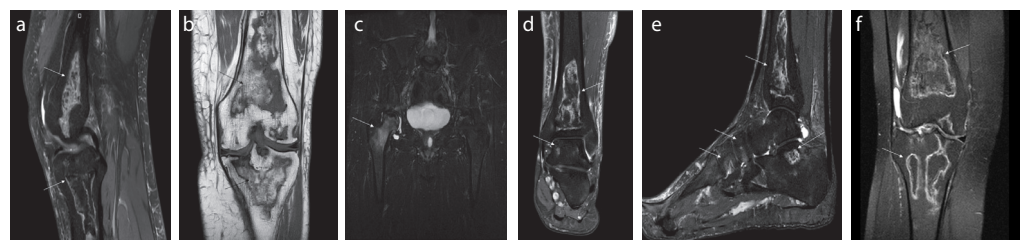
a-f. Multiple osteonecrotic areas (arrows) suggested by nuclear magnetic resonance imaging: Longitudinal short-T1 inversion recovery (STIR) (a) and coronal T1-weighted magnetic resonance image showing proximal tibia and distal femur section (b); coronal STIR magnetic resonance image showing proximal femur section (c); coronal STIR magnetic resonance image showing distal tibia and talus section (d); longitudinal STIR magnetic resonance image showing distal tibia, calcaneus, and first cuneiform bone section (e); and coronal STIR magnetic resonance image showing proximal tibia and distal femur section (f).
